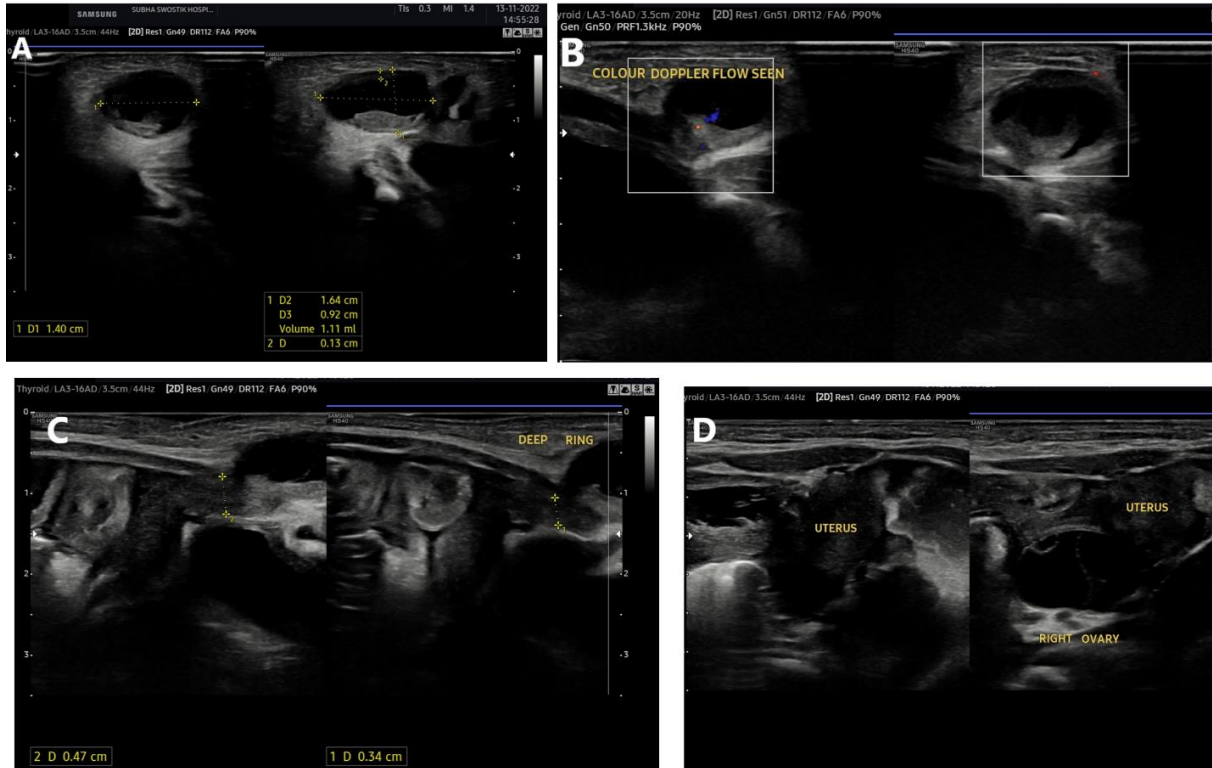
Ultrasound picture A-D. A, Showing left ovary in inguinal canal. B, Color flow within left ovary. C, Deep ring defect with adjacent ovary in the inguinal canal. D, Uterus and right ovary within pelvic cavity
